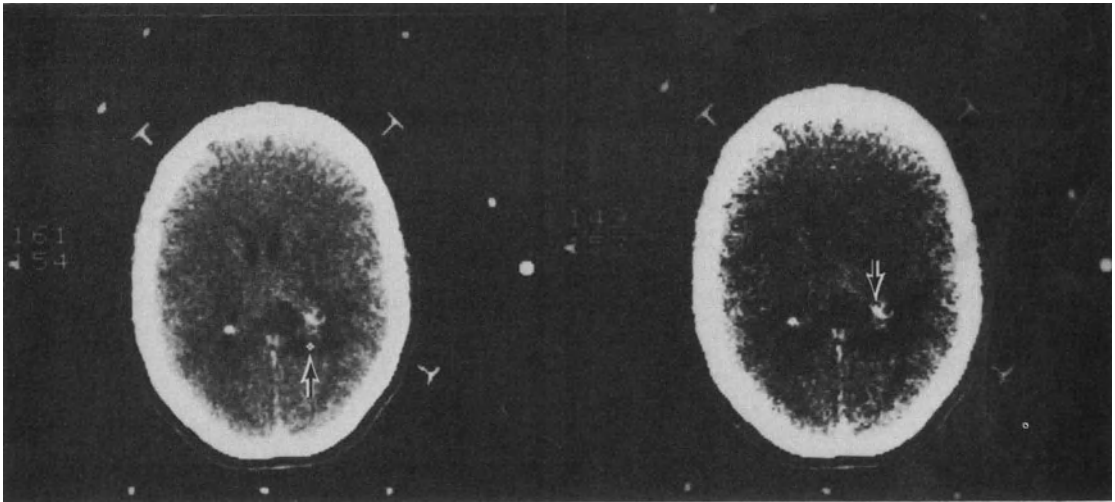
CT stereotactic biopsy at the posterior contrast-enhancing border of the lesion (*left*) demonstrated a few tumor cells classified as anaplastic astrocytoma (*arrow*). An additional biopsy (*right*) taken 7 mm anterior to the first target (*arrow*) revealed pleomorphic cells, endothelial proliferation, and necrosis characteristic of a glioblastoma.
